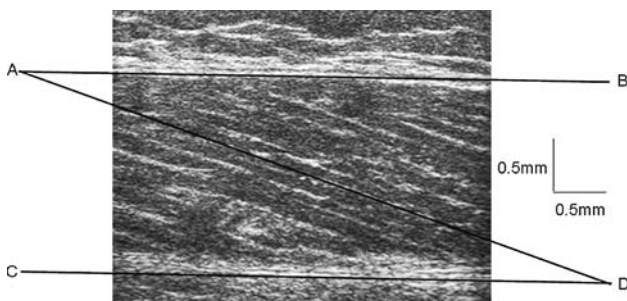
An ultrasound image of biceps femoris. The line (AB) represents the position of the superficial aponeurosis. The line (CD) represents the position of the deep aponeurosis. In order to measure FL and PA, a line of best fit was placed along the length of a fascicle, which joined lines AB and CD. The FL was calculated as the length of this line. The PA was calculated as the angle between lines CD and DA (Chleboun et al. 2001)
